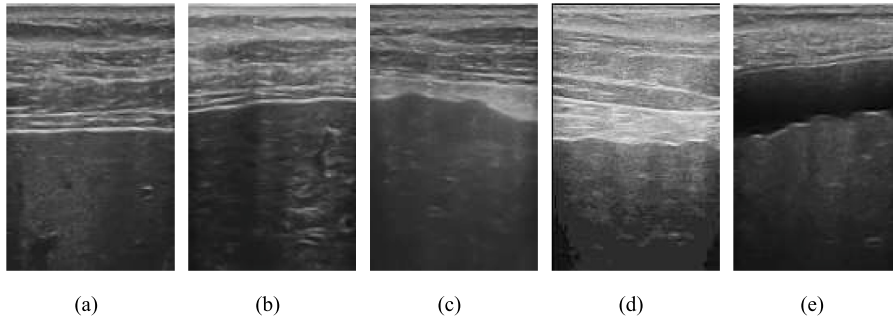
Liver ultrasound images at different stages.
